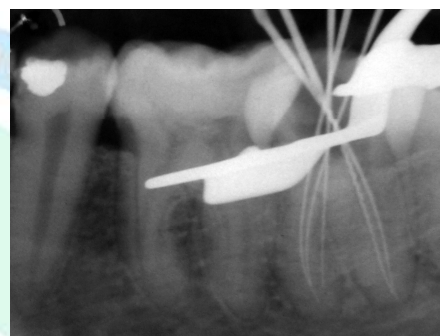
Radiograph showing verification of working length using an electronic apex locator
